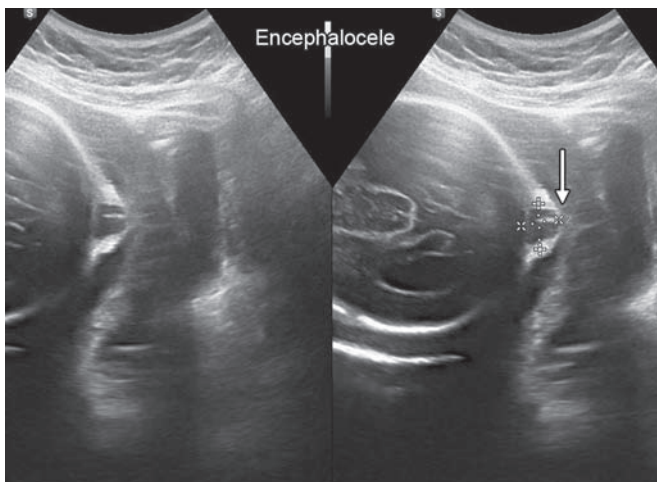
Ultrasound image of a case of encephalocele
